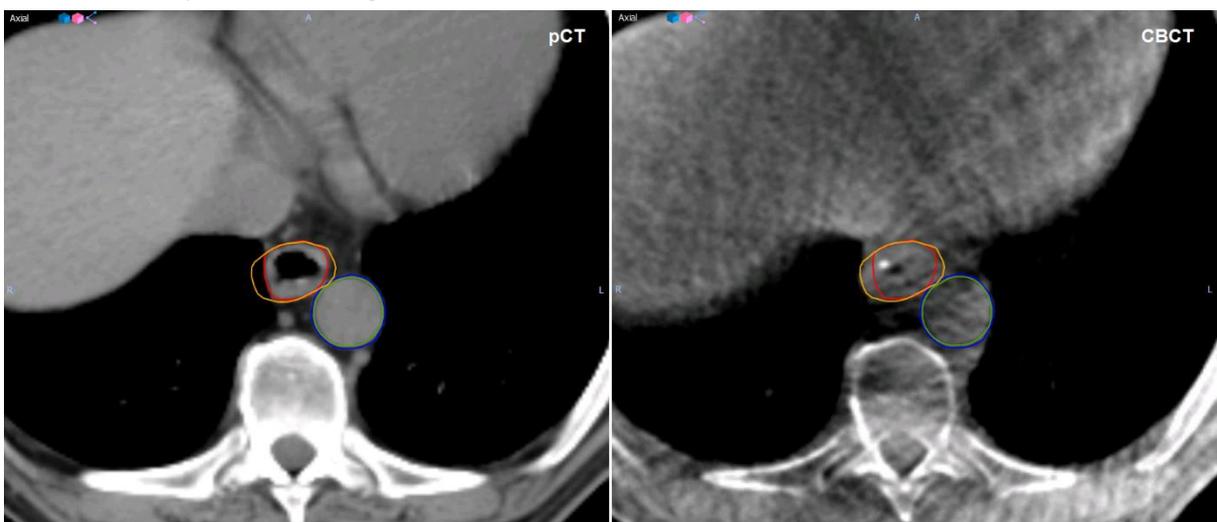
Structure delineations on pCT (left) and CBCT (right) in axial slice of the distal esophagus. Aorta and esophagus Delineation of pCT are blue and red, respectively. Aorta and esophagus delineation of CBCT are green and orange, respectively. The poorer image quality of CBCT is clearly visible, showing streak artifacts and a lower spatial resolution.
